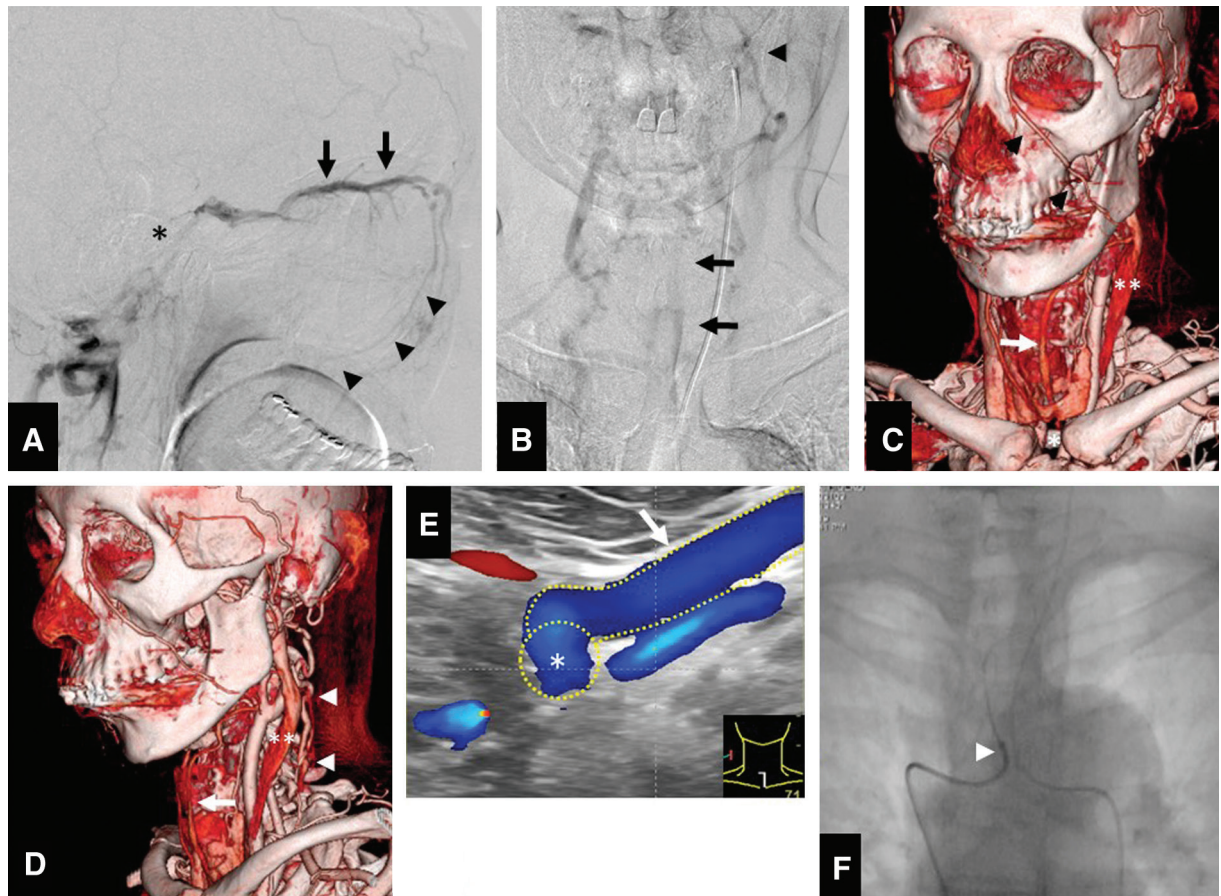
(A) Preoperative lateral view of the left external carotid angiogram showing left-sided CS-DAVF with venous drainage into the bilateral FV (arrowheads) via the SOV (arrows), and the highly narrowed left IPS (asterisk). (B) The outflow route of the FV (arrowhead) in the cervical region was unclear on DSA (arrows: ITV). (C and D) CTA showing the left FV (arrowheads) flowed out into the left brachiocephalic vein (asterisk) via the left ITV (arrows) (double asterisks: IJV; arrowheads: EJV). (E) US showing the left FV flowed out into the left brachiocephalic vein (asterisk) via the left ITV (arrow). (F) Catheterization to the FV was difficult due to the instability of the guiding catheter in the left brachiocephalic vein (arrowhead: tip of the guiding catheter). CS-DAVF: cavernous sinus dural arteriovenous fistula; CTA: computed tomography angiography; DSA: digital subtraction angiography; EJV: external jugular vein; FV: facial vein; IJV: internal jugular vein; ITV: inferior thyroid vein; US: ultrasonography
